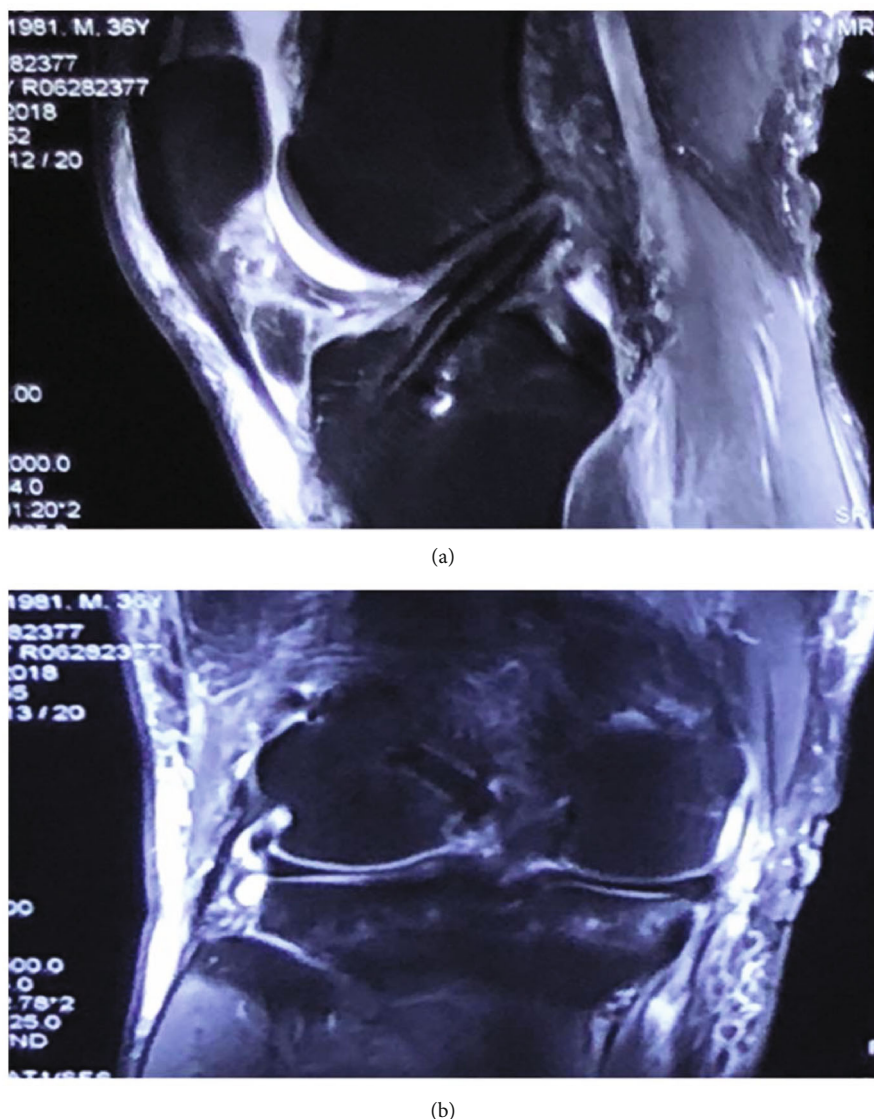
MRI evaluation following ACL reconstruction using an augmented graft. Sagittal view: normal shape of the graft in the joint and synthetic material wrapped around the autogenous tendon. Coronal view: femoral tunnel is completely filled with the graft.
